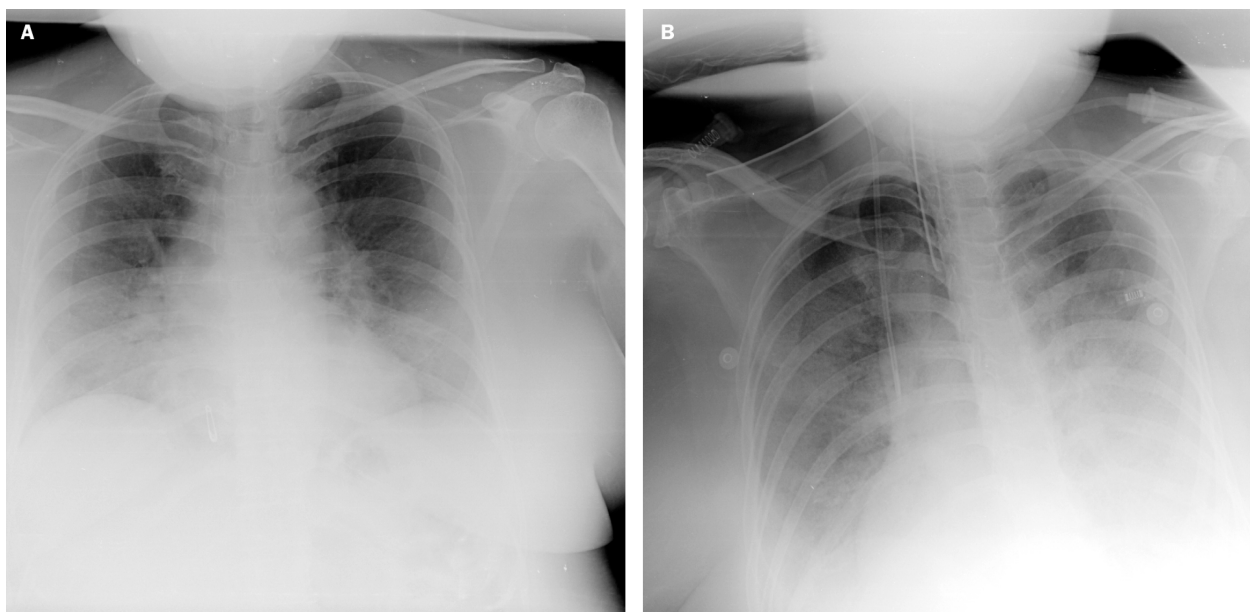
Chest radiograph on initial presentation (A) and after 8 days (B).
